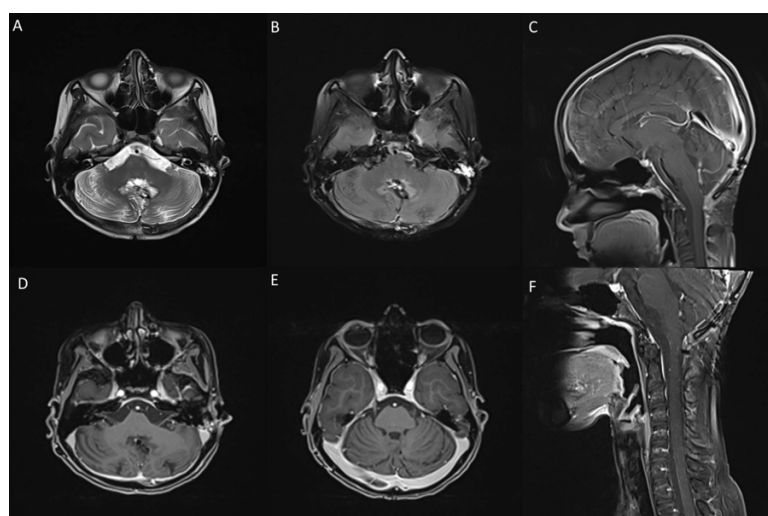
Final follow-up MRI after chemoradiotherapy.
